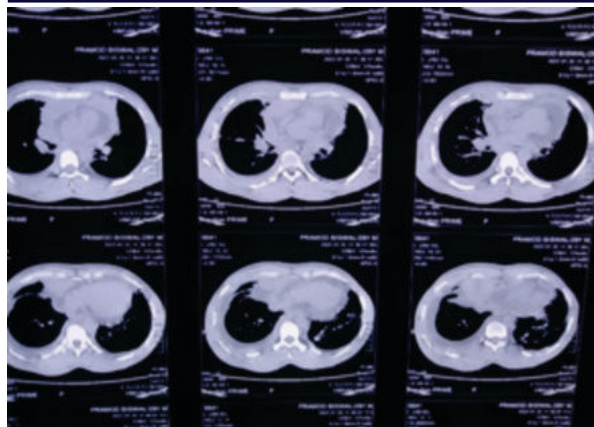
CT thorax showing anterior mediastinal mass, pericardial effusion & bilateral pleural effusion.
